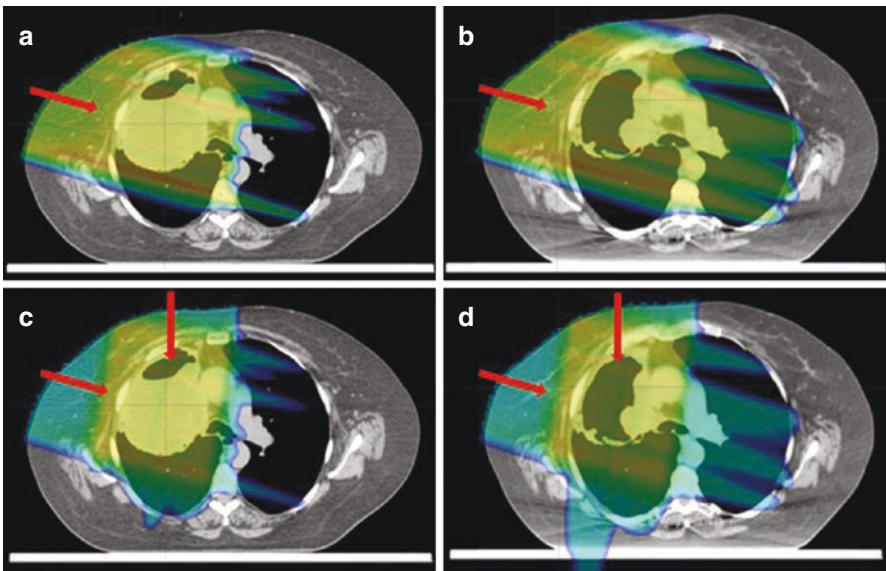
The effect of lung tumor shrinkage on proton dose distribution. The second CT scan was taken at 3 weeks into treatment course. (a) shows a single RAO field from the nominal treatment plan; and (b) shows the effect of tumor shrinkage on the RAO field. (c) shows the complete two-field nominal plan; and (d) shows the effect of tumor shrinkage on the two-field plan
